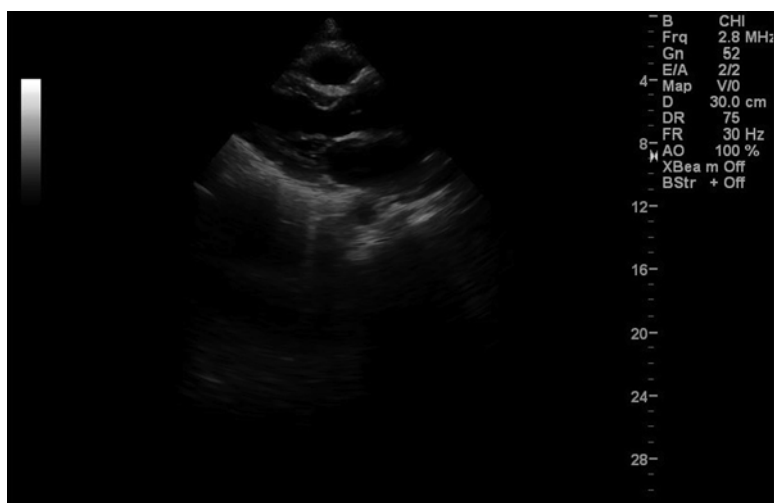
Showing the left parasternal long axis (PLAX) view of the heart wrong depth settings. The depth is set too deep and thus the heart looks much smaller in size. Note that the depth setting in this example is set at 30 cm
